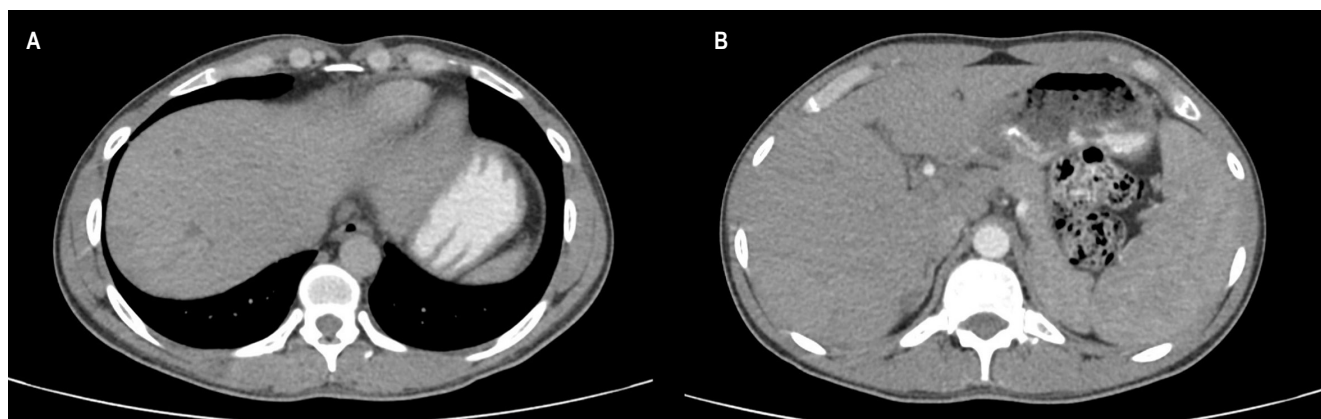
Follow-up computed tomography of the abdomen and pelvis. A. Irregular subcapsular hypodense lesion in segment VII measuring 23×18 mm. B. Additional rounded hypodense lesion in segment VII measuring approximately 15×18 mm. Findings were primarily attributable to hepatic abscesses, with a reduction in size compared with the previous study. Author's file.
